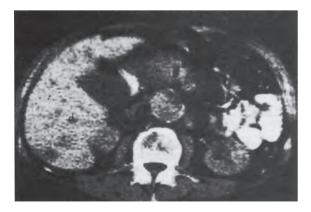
CT scan showing typical appearance of carcinoma of the pancreas, consisting of a mass (m) in the head of the pancreas, a distended gallbladder (g) and dilated intrahepatic ducts (d). Incidental note is made of an aortic aneurysm which was better seen in more caudal sections.
